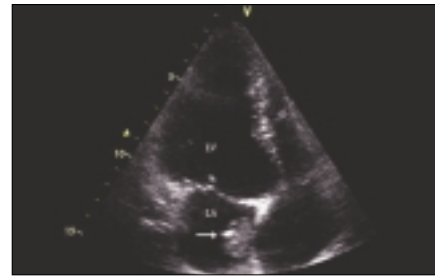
The transthoracic image of left atrial mass
